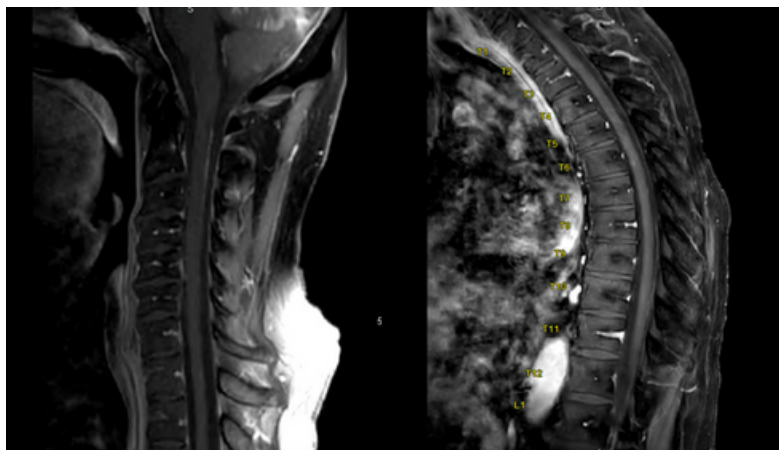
MRI C spine w/wo (T1 sagittal post)
